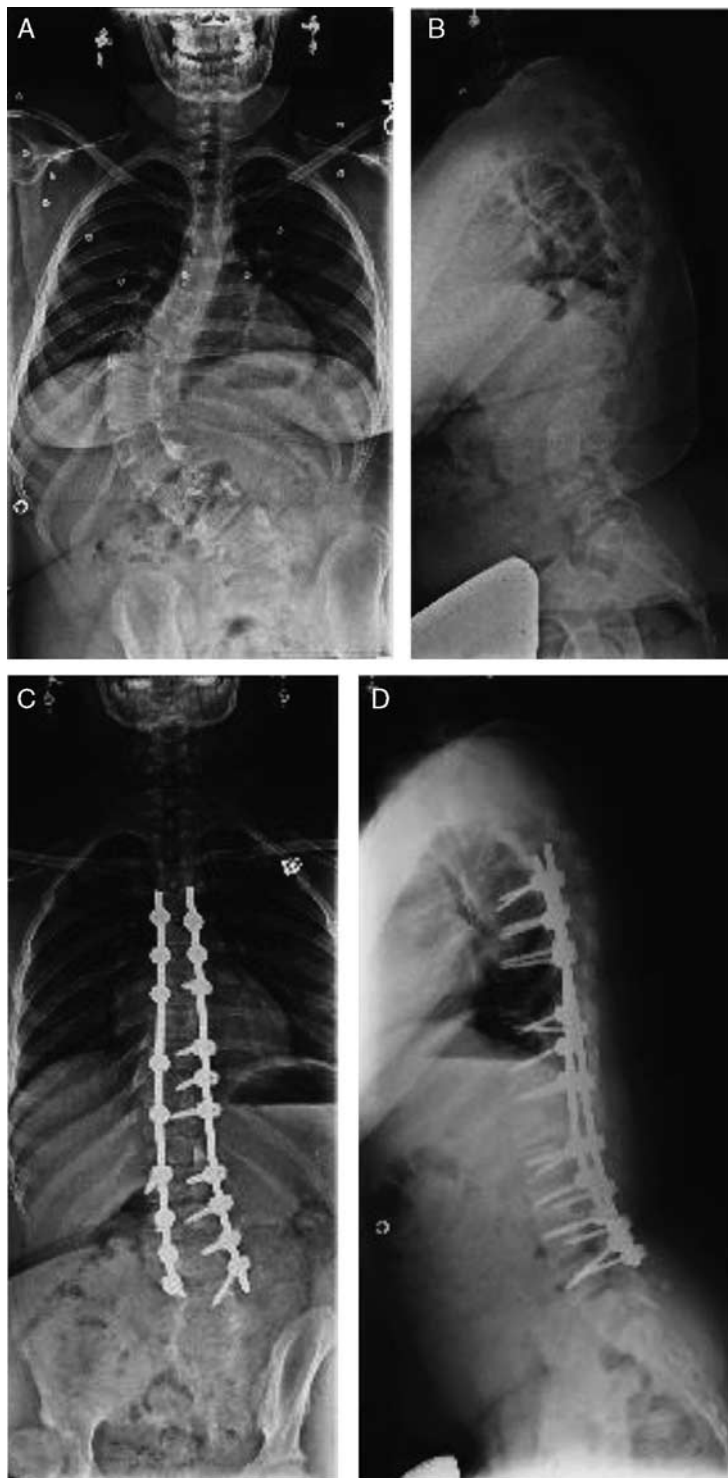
This 13-year-old girl with myelodysplasia and a 75-degree curve was ambulatory at baseline. She underwent posterior spinal fusion with an asymmetrical pedicle subtraction osteotomy at the apex of her curve and spinal cord untethering. Motor evoked potentials were lost at the time of rod insertion and returned with removal of the rod. To remedy concerns for canal translation and screw placement on the concave side of the curve, we repositioned 1 screw and removed 1 screw with motor evoked potentials intact at closure. Although motor evoked potentials are difficult to monitor in patients with myelodysplasia at baseline, a switch from anesthetic gas to total intravenous anesthesia (remifentanyl and propofol) improved intraoperative signals and she was successfully monitored through motor evoked potentials. A, Preoperative anteroposterior radiograph. B, Preoperative lateral radiograph. C, Postoperative anteroposterior radiograph. D, Postoperative lateral radiograph.
